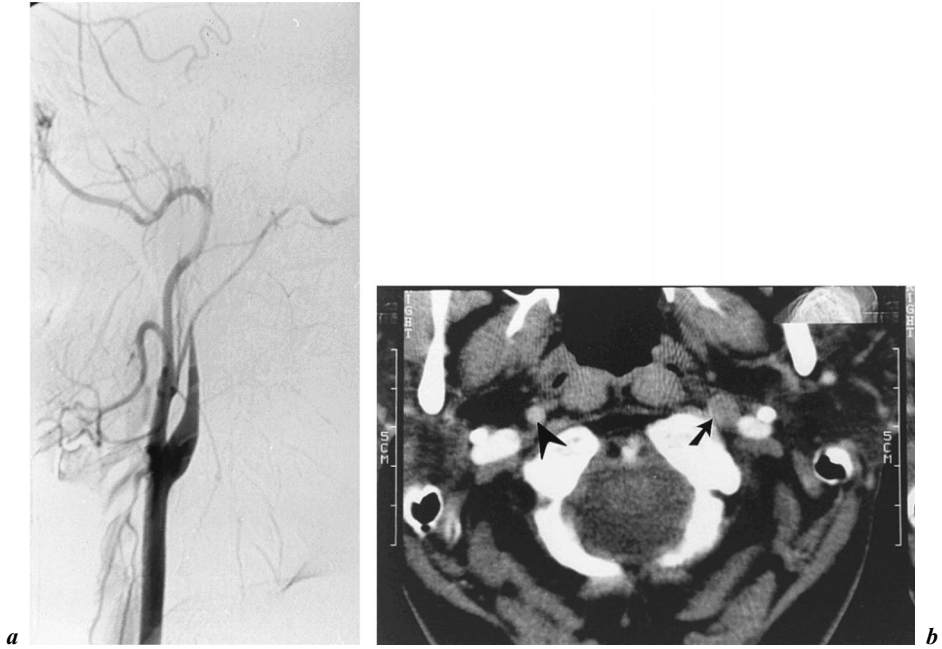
a* Occlusive type dissection of the left internal carotid artery (ICA) on angiography. *b* Helical CT demonstrates the increased external diameter (arrow) of the ICA compared with the contralateral side (arrowhead).
